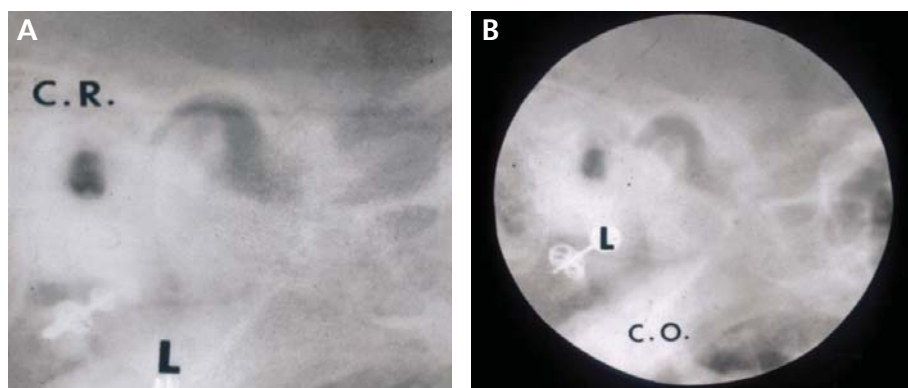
These two X-ray images were taken from a single patient whose head position was fixed and the mandible was at the retracted (A) and non-retracted (B) jaw positions. Evident difference in condylar position can be seen.
